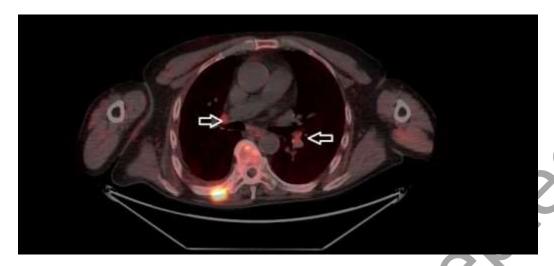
The arrows demonstrate increased FCH uptake in bilateral hilar lymph nodes (SUVmax up to 3.7), suspicious for metastatic spread of pulmonary carcinoid.
